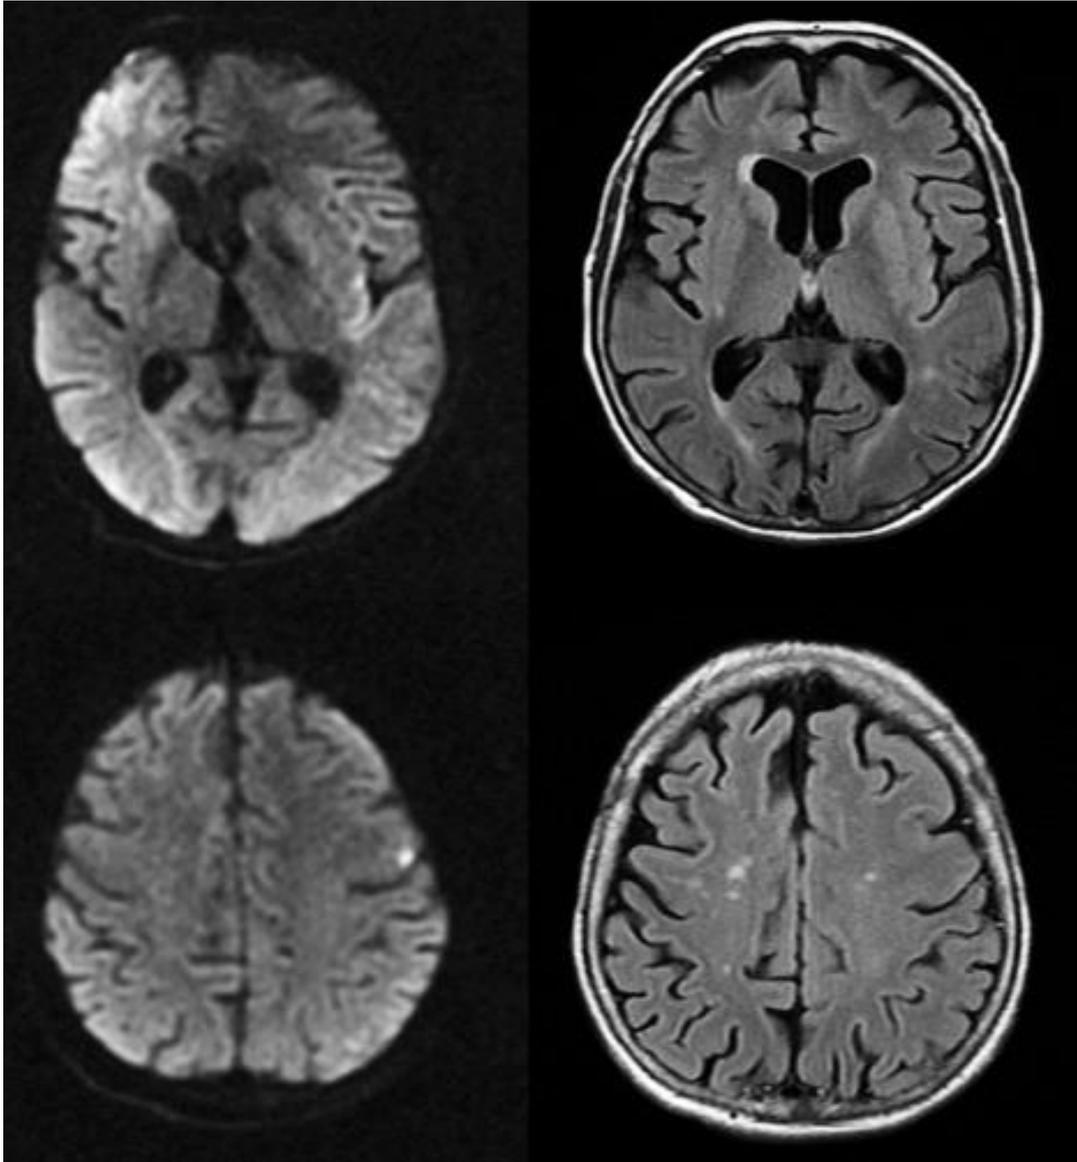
Example for partial mismatch. Superior row: left insular DWI hyperintensity with corresponding FLAIR signal change. Inferior row: the left frontal cortical DWI lesion is not yet visible on FLAIR.
